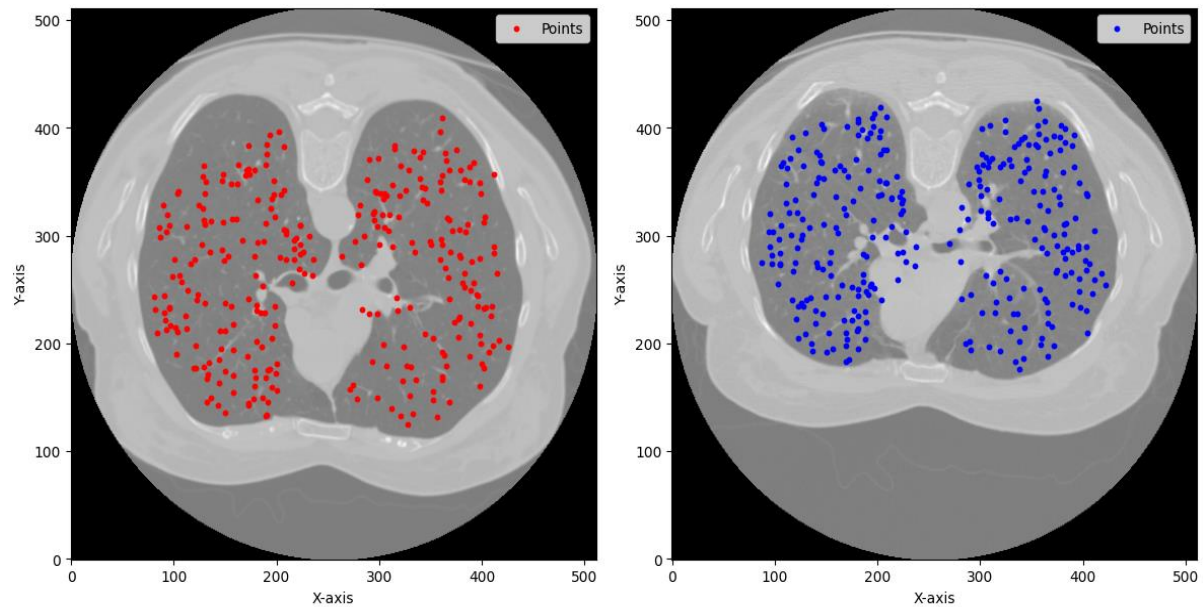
The inhale iBH-CT (left) slice and the exhale eBH-CT (right) slice of COPD1 image with corresponding landmark points.
